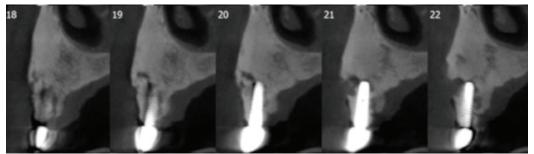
In CBCT, it was noted that significant bone loss and sequestrum formation around the implant.
